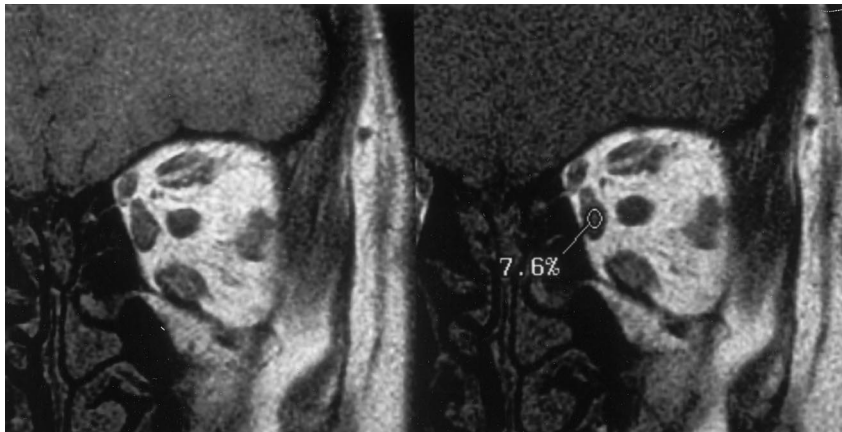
Patient with euthyroid Graves' ophthalmopathy. T1-weighted image without (left) and with (right) off-resonance saturation pulse applied at 500 Hz frequency offset. Medial rectus muscle shows very little (7.6%) signal suppression. Comparison with Figure 2 reveals medial rectus size and signal similar to healthy control subject, but with grossly abnormal suppression related to the near-resonance saturation pulse. Maximum cross-sectional area is 26 mm² and MR signal is 257.5. Window width and level settings are constant.
